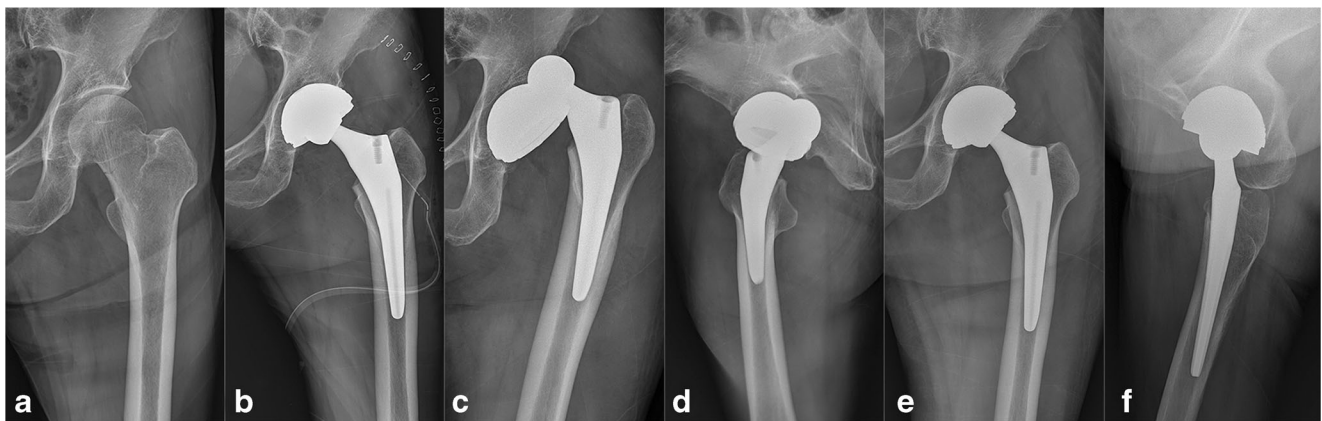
Dislocation of total hip arthroplasty with a dual mobility cup treated by closed reduction. a A partially displaced Garden III intracapsular femoral neck fracture with a complete fracture extending to the medial cortex of the femoral neck, sustained by a 75-year old woman after a fall from standing height. b Postoperative radiograph
